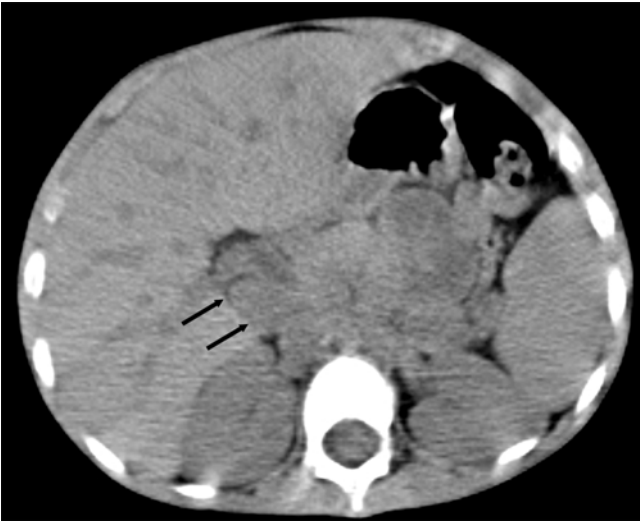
There were no ^{18}F -FDG uptakes in abdominal lymphadenopathies seen on CT images of PET/CT (arrows).
